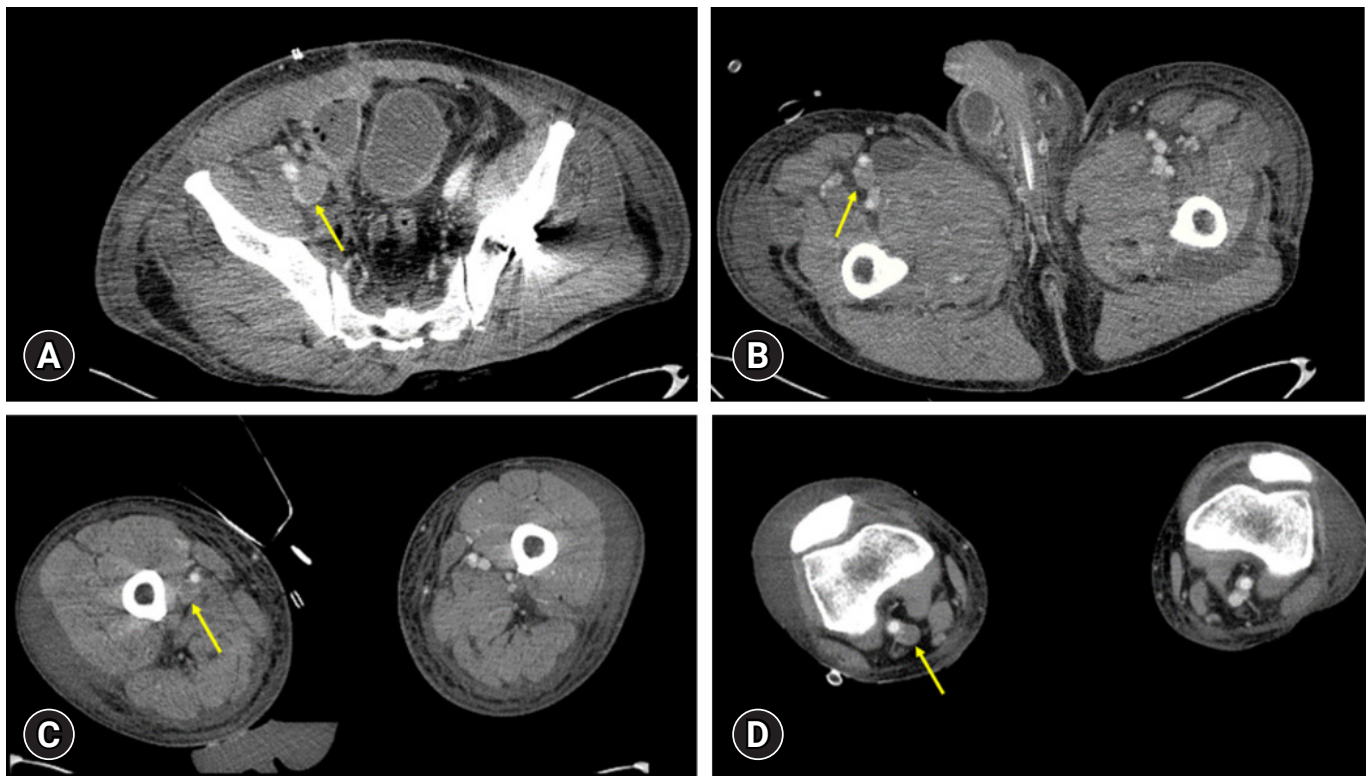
Computed tomography angiogram on postoperative day 14. Deep vein thrombosis (arrows) from the ruptured right external iliac vein to popliteal vein. (A) The remnant right external iliac vein. (B, C) Femoral vein. (D) Popliteal vein.
